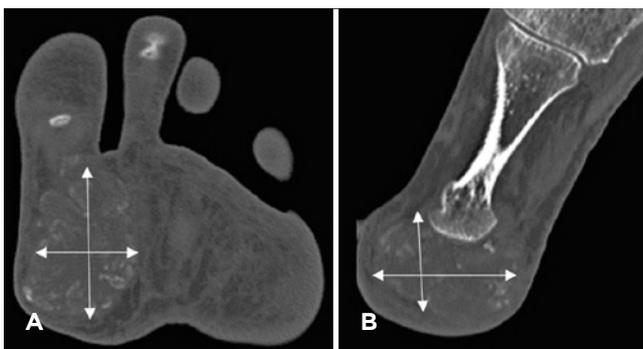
(A) CT scan axial image showing calcification within the lesion. (B) CT scan sagittal image showing no cortical breach of the metatarsal head by the lesion.
